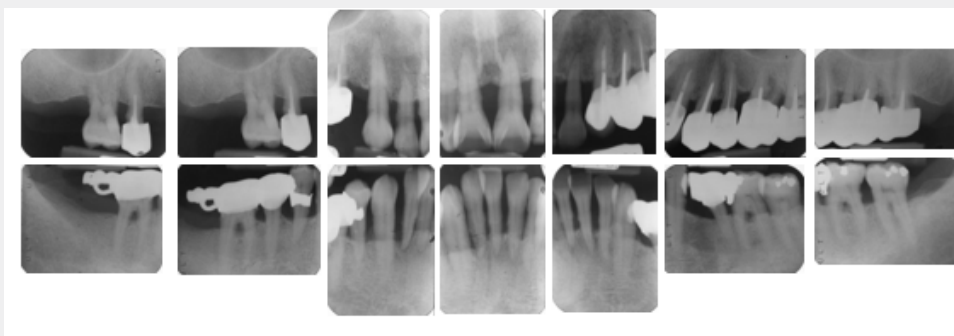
The patient affected severe advanced periodontitis with secondary occlusal traumatism (SOT) via full mouth radiographic x-ray before treatment (4/19/1994).
